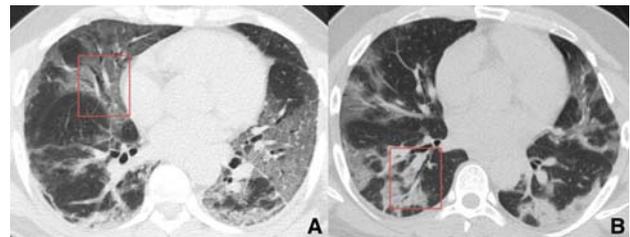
CT images of two different patients with COVID-19 with the 'air bronchogram sign' (red box in A and B) in the background of GGO and consolidation.
